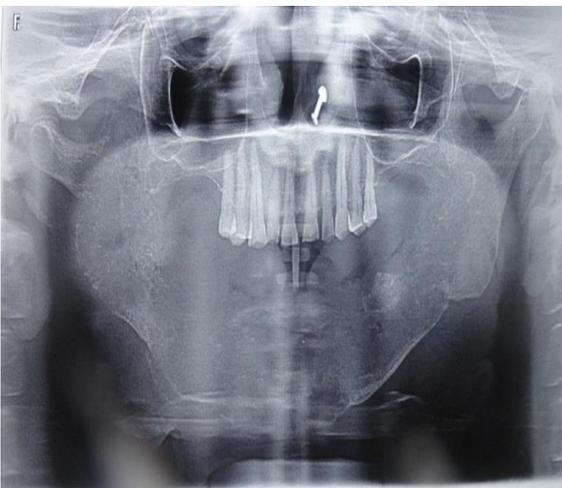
Radiograph reveals a lytic lesion in the mandible extending bilaterally towards condyles
